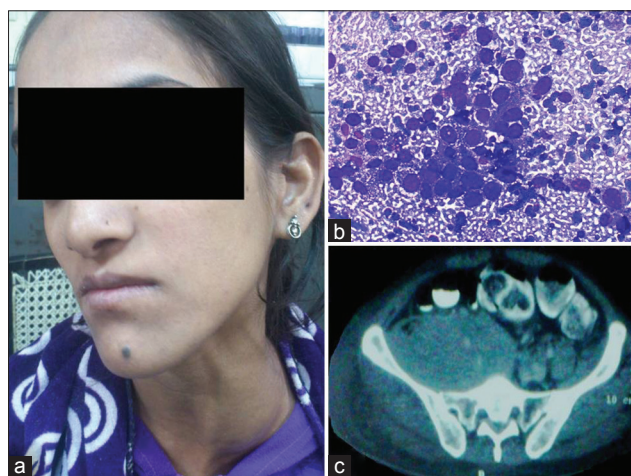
(a) Left side neck swelling which moved with deglutition (b) Fine needle aspiration cytology smears showing tumor cells against a tigroid background (Giemsa, ×40) (c) Retroperitoneal mass in the posterior abdominal wall seen on computed tomography abdomen
